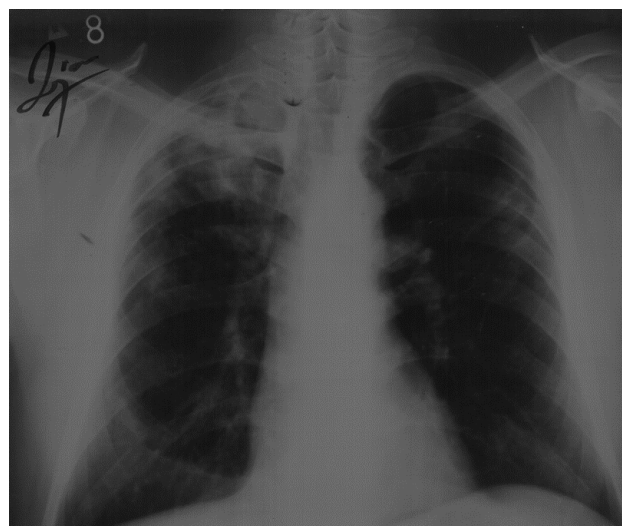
Chest radiography made in 2002 showed consolidations in right upper and mid lung lobe and left mid lobe.
